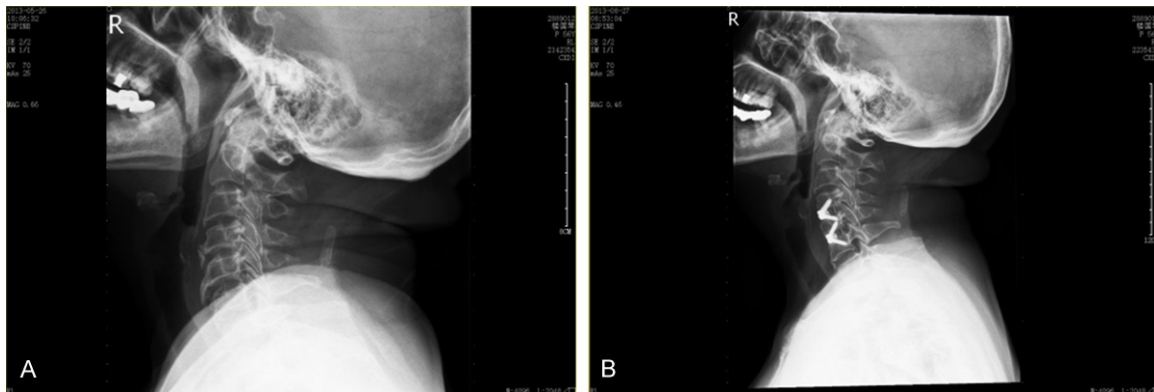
Preoperative and postoperative plain radiographs of cervical vertebral in patients with Zero-P treatment. A. Preoperative x-ray showed degeneration and abnormal physiology curvature of cervical vertebra. B. Postoperative x-ray showed good internal fixation and physiological curvature improvement.
